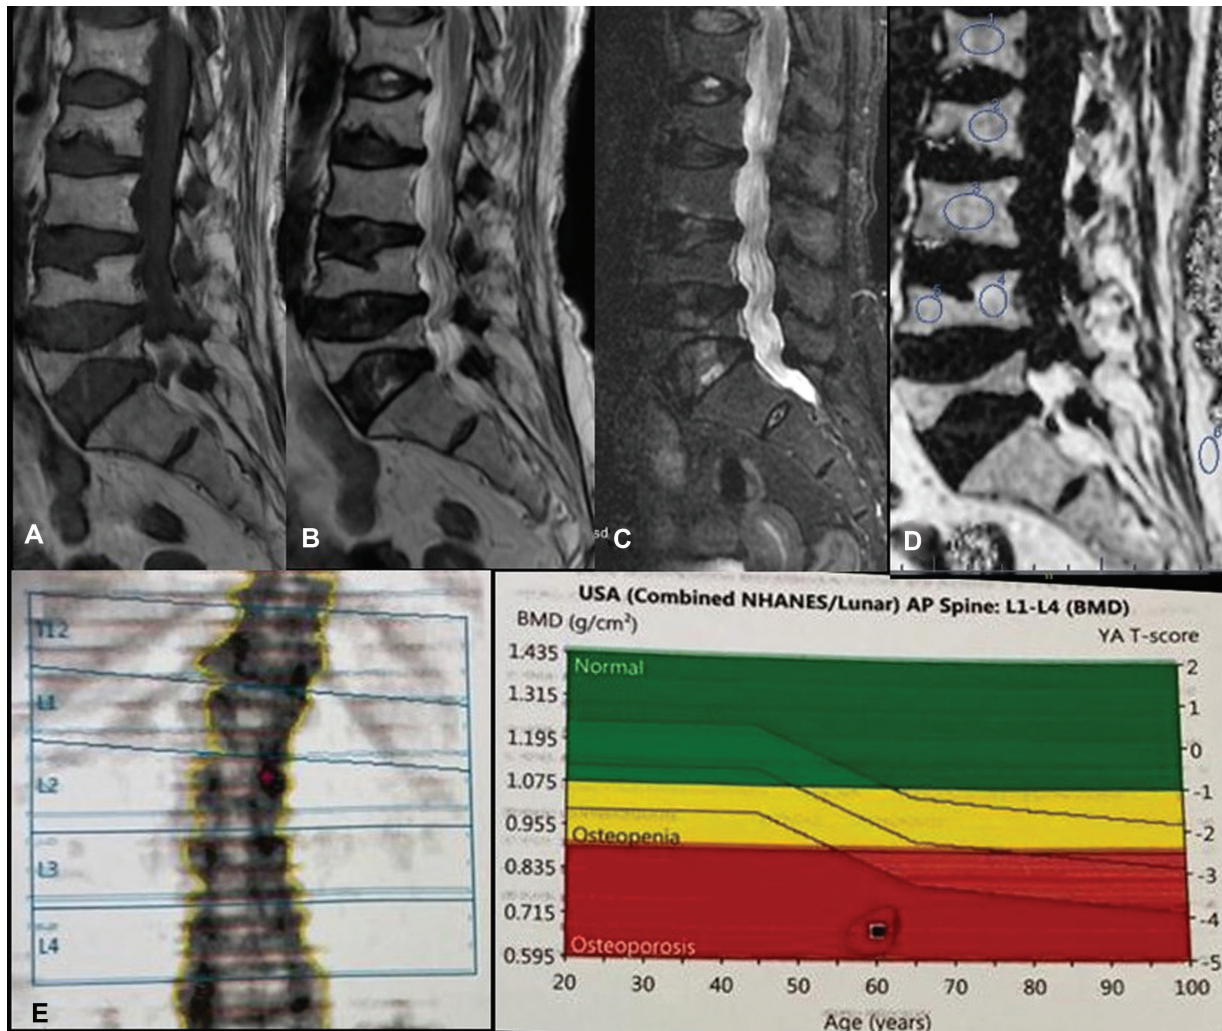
Magnetic resonance imaging (MRI) lumbar spine and bone mineral density (BMD) in a 61-year-old osteoporotic female with vertebral fracture. Routine T1-weighted imaging (T1WI) (A) and T2WI (B) show intervertebral disc desiccation at all levels and marginal osteophytes, central wedging of L2, L4, and L5 vertebra. There was minimal focal marrow edema at the lower endplate of L3 vertebra on short tau inversion recovery (STIR) sequence (C). Fat fraction of 75 was obtained from iterative decomposition of water and fat with echo asymmetry and least-squares estimation-intelligence quotient (IDEAL-IQ) sequence (D). T-score of -4.2 was obtained from dual-energy X-ray absorptiometry (DXA) (E).
